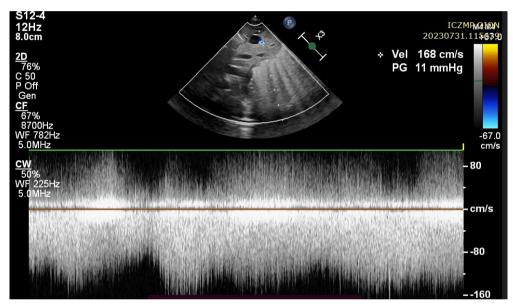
Postnatal ultrasound of a neonate showing a vessel with flow characteristics typical of blood flow restriction
